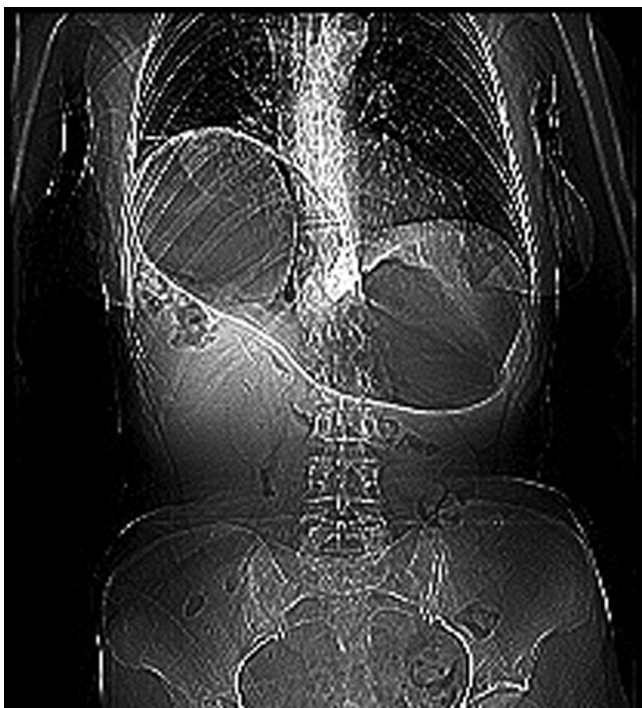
Abdominal X-ray image; eventration of the right diaphragm and a diaphragmatic hernia.
